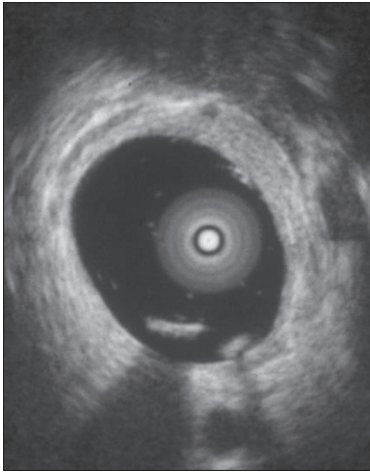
Common bile duct stone seen on intraductal ultrasonography
